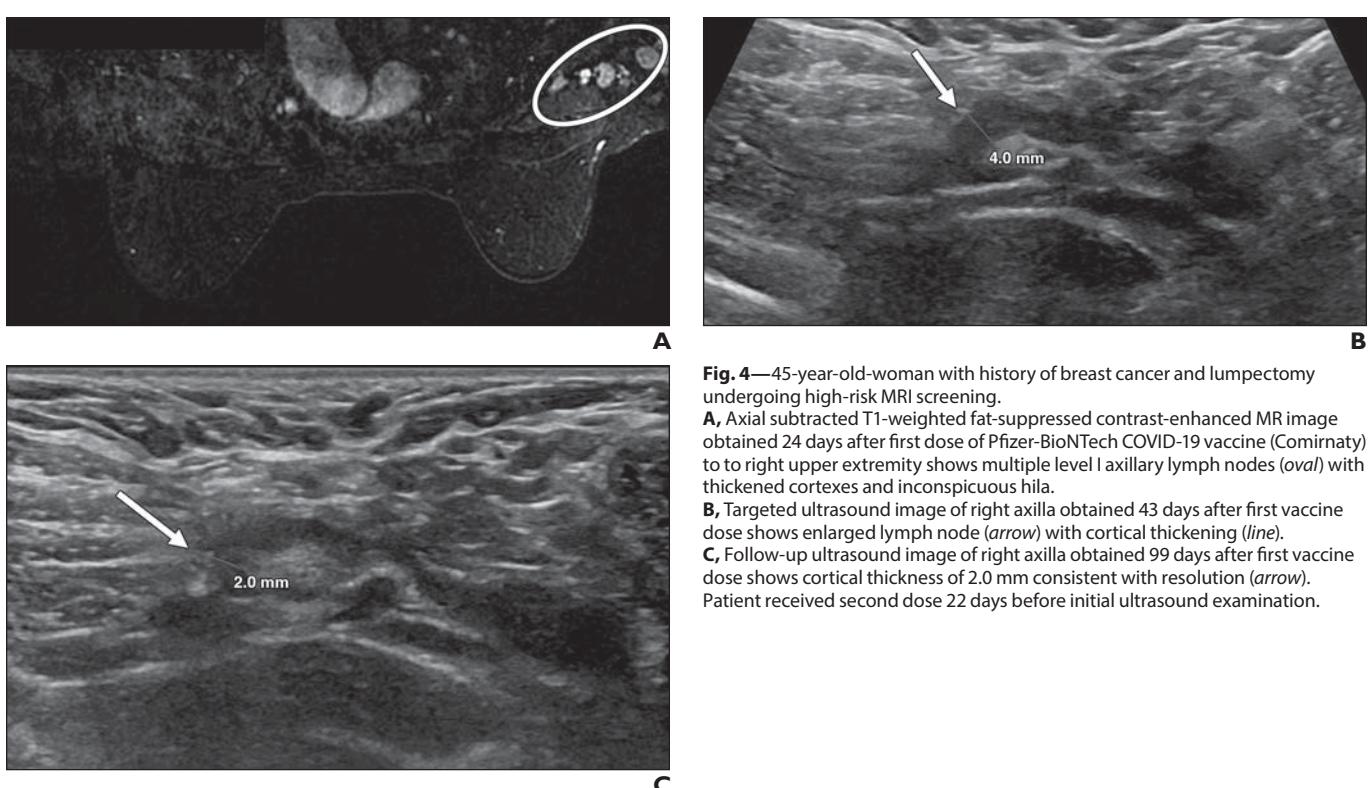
45-year-old woman with history of breast cancer and lumpectomy undergoing high-risk MRI screening.
